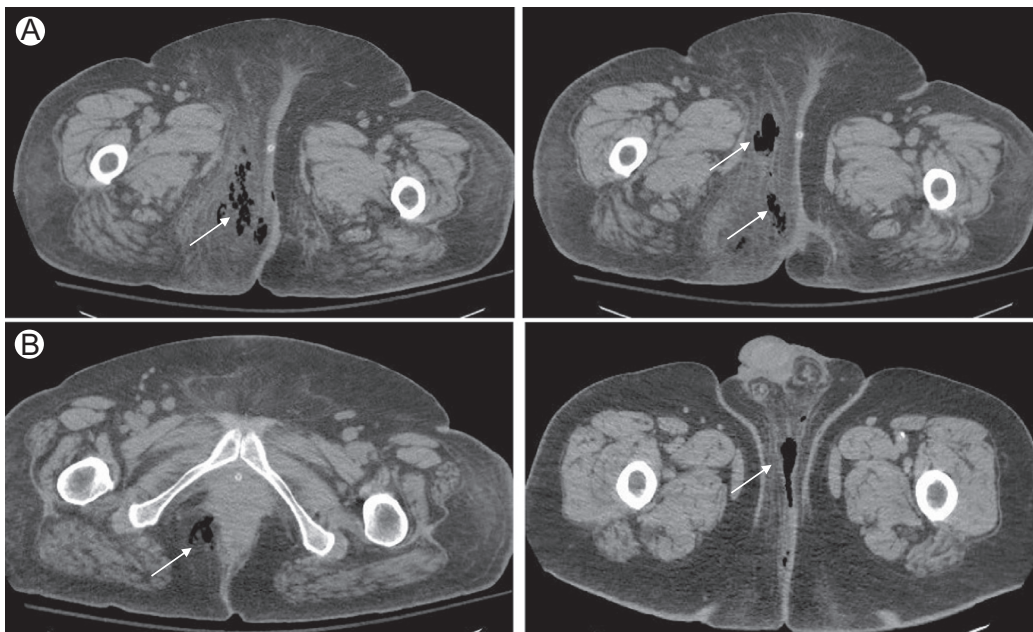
(A) *Fournier gangrene*: pelvic CT shows soft tissue gas seen in the perineum (arrows). (B) Pelvic CT in a different patient shows soft tissue gas along the the ischiorectal fossa on the right as well as in perineum and base of the scrotum at midline (arrows).
